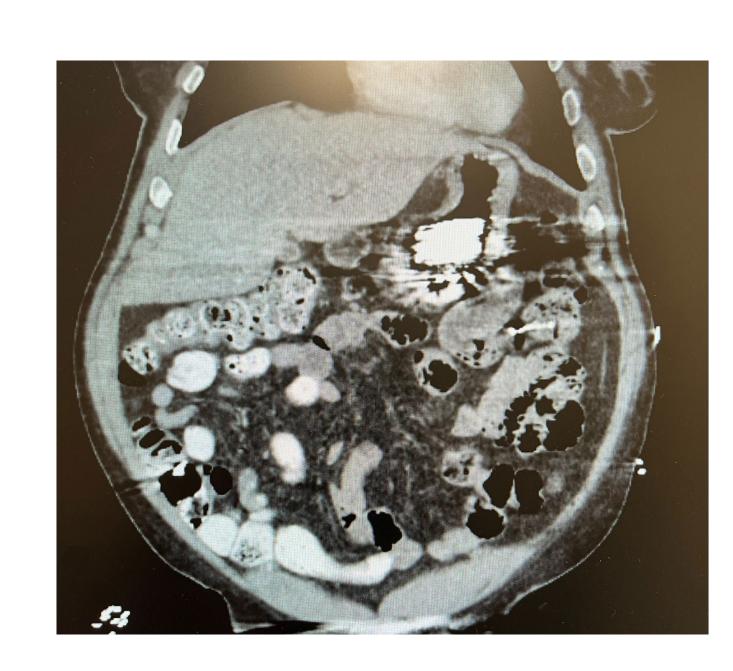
CT Abdomen/Pelvis with linear metallic foreign bodies.
